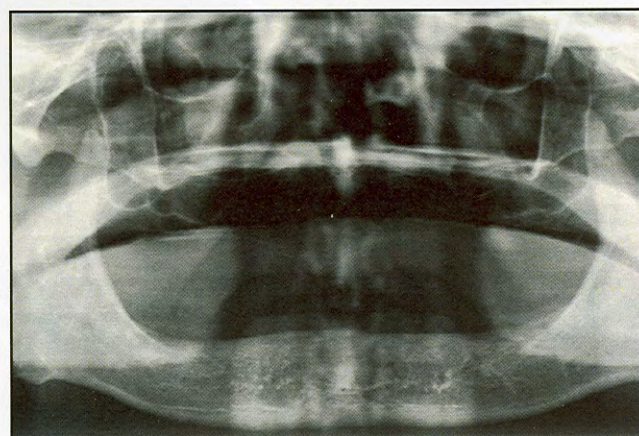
Preoperative panoramic radiograph showing an atrophic mandible.
